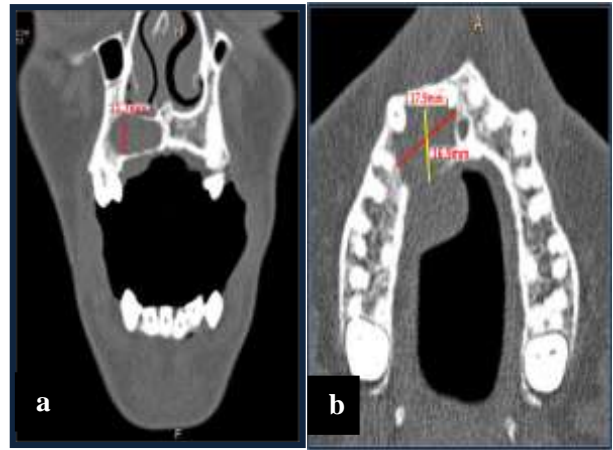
(a) Coronal CT image showing supero-inferior dimension of lesion; (b) Axial CT image showing antero-posterior and bucco-palatal dimension of lesion.
